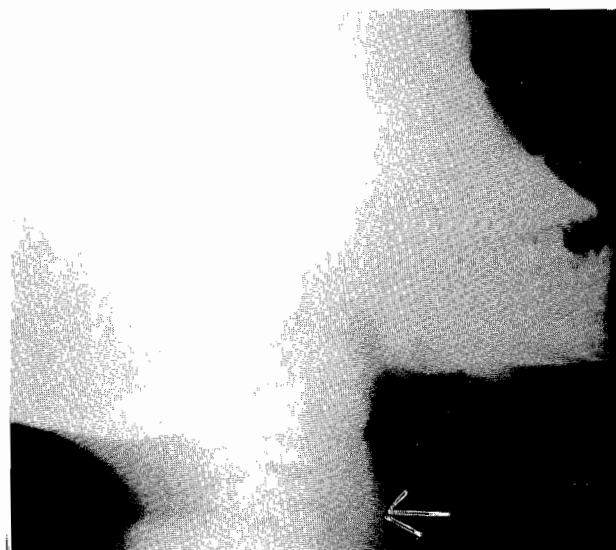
Lateral view of soft tissue radiograph of the patient showing increased pre-vertebral soft tissue shadow with irregular margin (white arrows) and loss of cervical lordosis.
